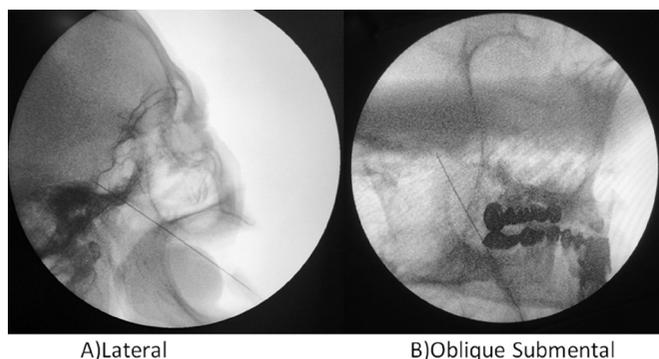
Trajectory of the catheter needle in lateral (A) and oblique submental (B) cranial radiograph images. Permission to publish the images was obtained from the authors of the accompanying article. The figure is based on original photographs from the author's archive (15)
